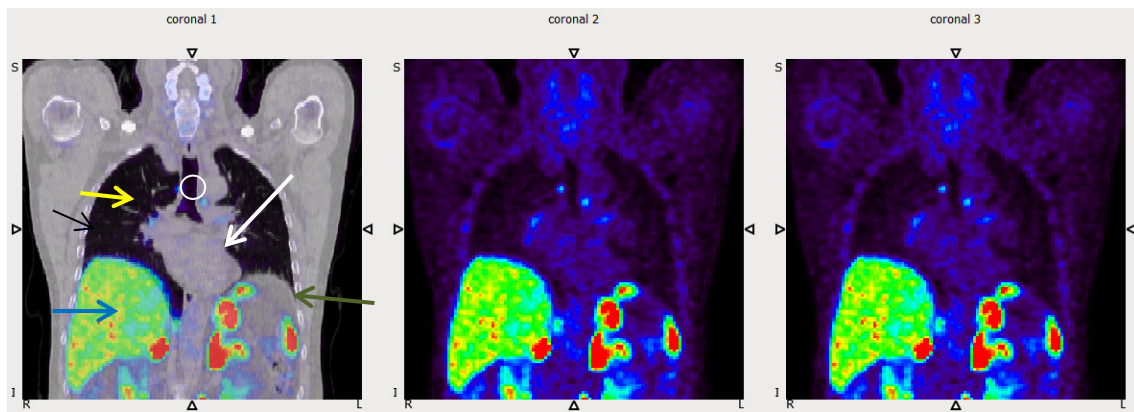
Patient 07: Fused PET<sub>0</sub>/CT image (left) to locate the lung, rib bone, liver, heart, and spleen indicated by yellow, black, blue, white and green arrows, respectively. The white circle indicates the location of a lesion between lung, soft-tissue and trachea. The PET<sub>0</sub> (centre) and PRC<sub>5</sub> (right) images.
